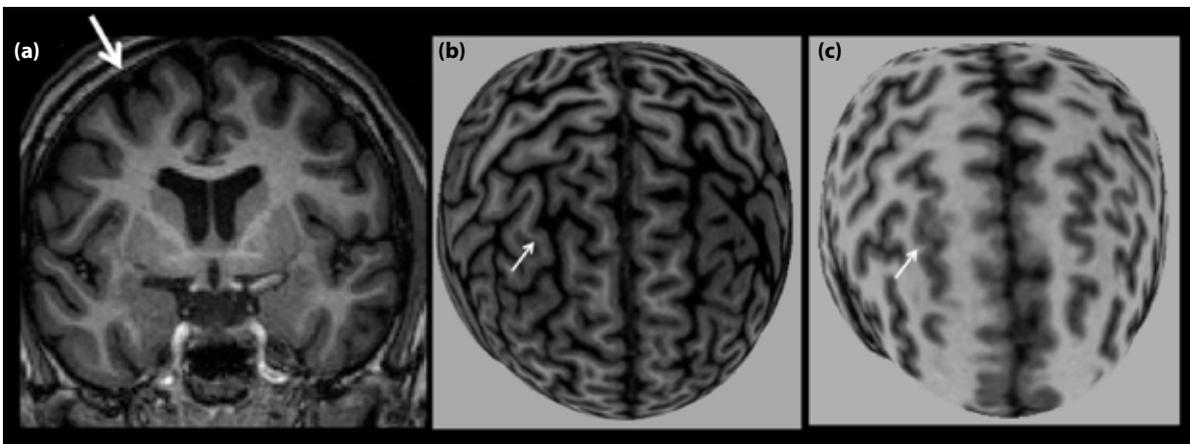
T1WI coronal MRI sequence (a) and curvilinear reconstruction (b) showing changes in the pattern of brain sulci and gyri in the superior and middle frontal gyrus. Deeper curvilinear reconstruction (c) shows better the FCD, characterized by blurring of white and grey matter transition and cortical thickness.
